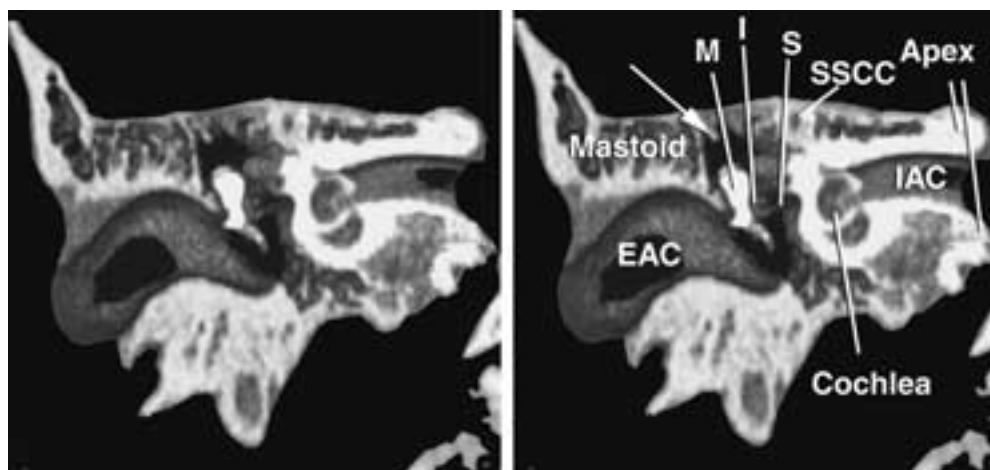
Thick coronal CT image (frontal view) showing the relationship of the structures within the temporal bone. The external ear including the external auditory canal (EAC) forms the lateral part of the ear. The middle ear contains the ossicles (*M* = malleus; *I* = incus; *S* = stapes). The labyrinth, situated central to the middle ear, includes the cochlea, vestibule, and semicircular canals (SSCC = superior semicircular canal). The more medial portion of the temporal bone includes the petrous apex and the transiting internal auditory canal (IAC). The mastoid is an extension from the antrum, which is an extension from the middle ear. The mastoid air cells can extend to the most lateral plate of the temporal bone. Koerner's septum (arrow).
